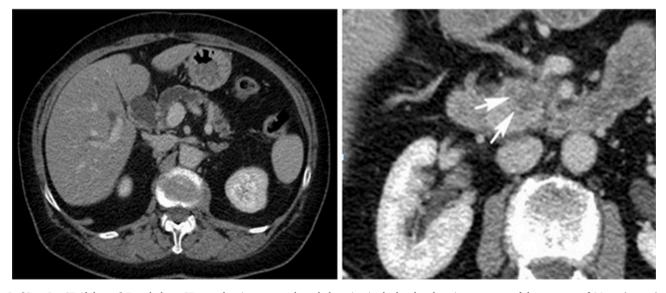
[Case 2 – CT Abdomen] Portal phase CT-scan showing a parenchymal alteration in the head and uncinate process of the pancreas of 26mm (arrows); fine needle aspiration confirmed the presence of adenocarcinoma.
